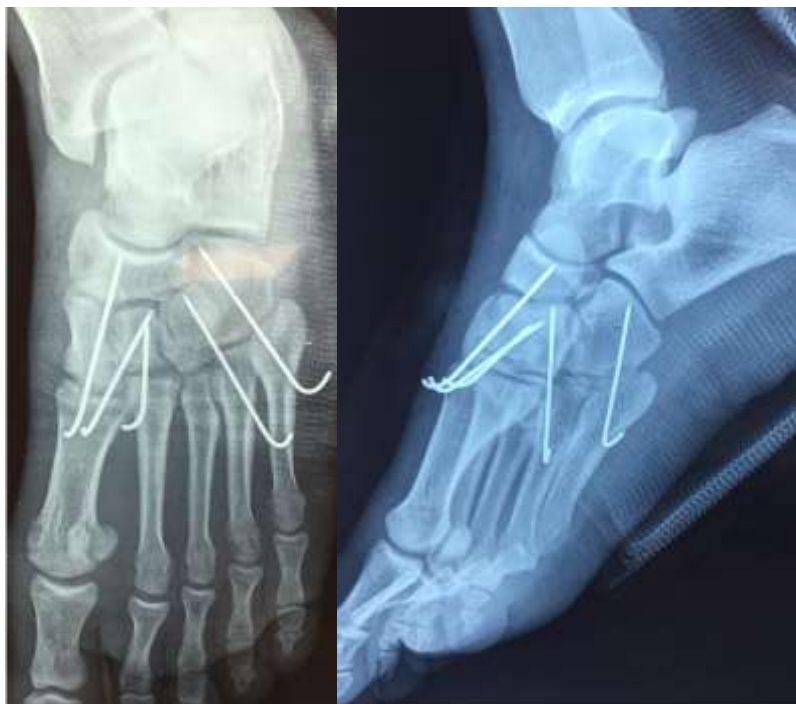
(a, b): Postoperative X-rays of Face and profil of the right foot showing anatomical reduction.
